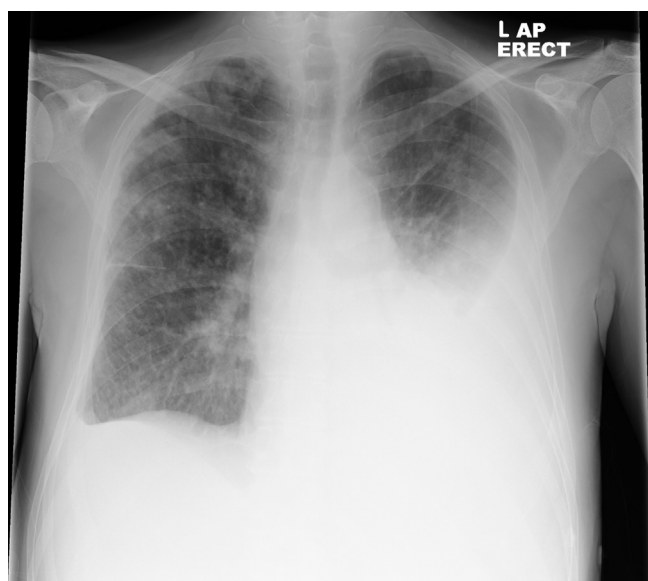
Chest X-ray showing a large left pleural effusion, a small right pleural effusion and some nodules and consolidation in both lungs.
